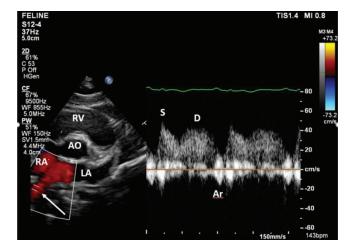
Spectral evaluation of pulmonary venous flow uses PW Doppler only. The gate is placed entirely in the vein (arrow). The more parallel to flow the Doppler cursor is, the more accurate the venous flow velocities are. To the right the spectral display shows S, D, and Ar flow.
